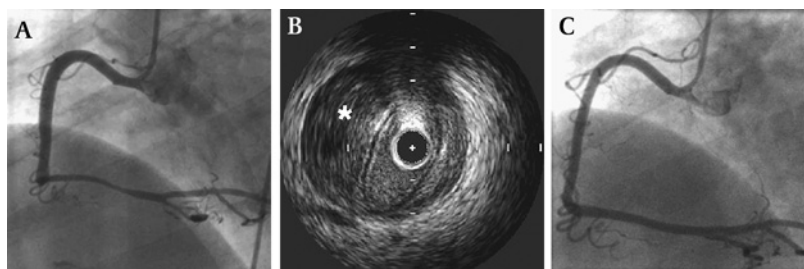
A: Left anterior oblique (LAO) view showing long stenosis of the right coronary artery. B: Corresponding intravascular ultrasound examination showing haematoma (asterisk) compressing the true lumen. C: LAO projection showing a favourable angiographic appearance at follow-up. Reproduced with permission from Arnold *et al.*²⁰
